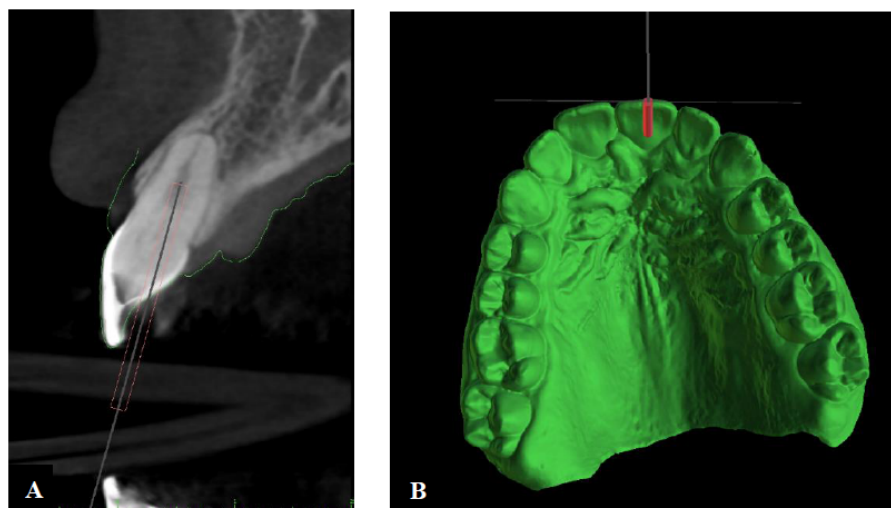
A) Computerized Cone Beam Tomography. B) 3D Model.
